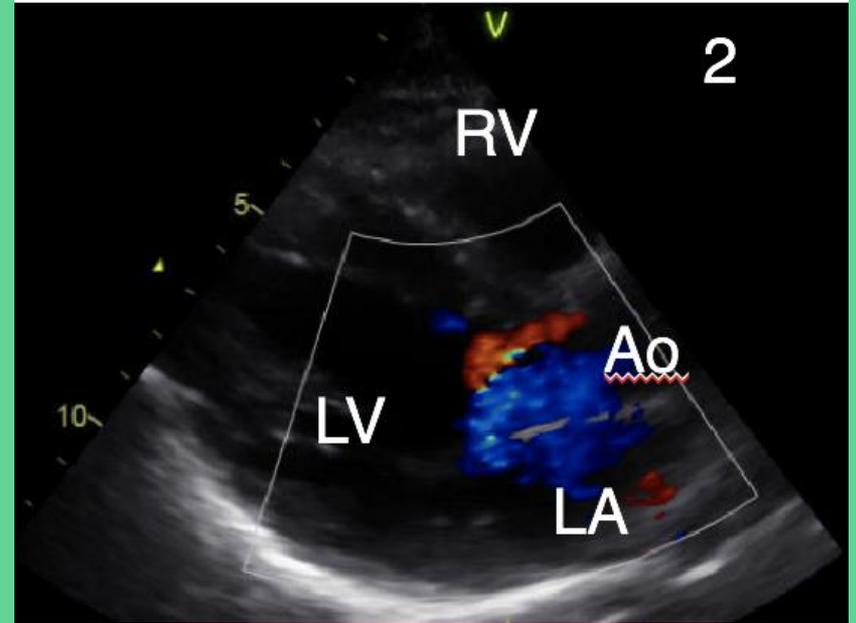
Parasternal long-axis TTE showing severely decreased EF <math>< 20\%</math>
